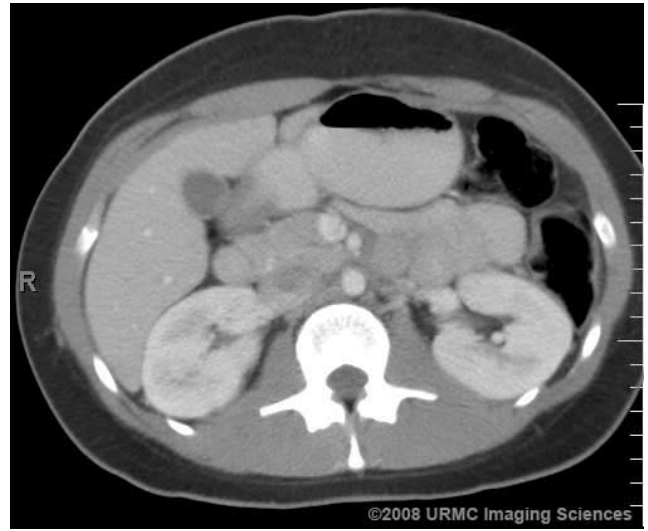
Contrast-enhanced axial CT one month following therapy exhibits resolution of renal vein and IVC thrombosis.
